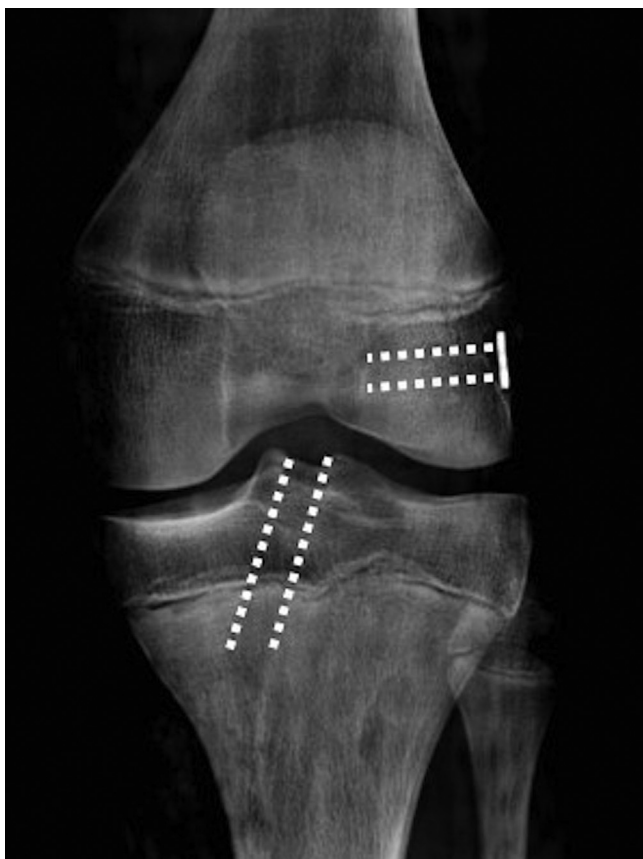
Relationship between the physis and the tunnels: a postoperative radiograph of method B (left knee).
